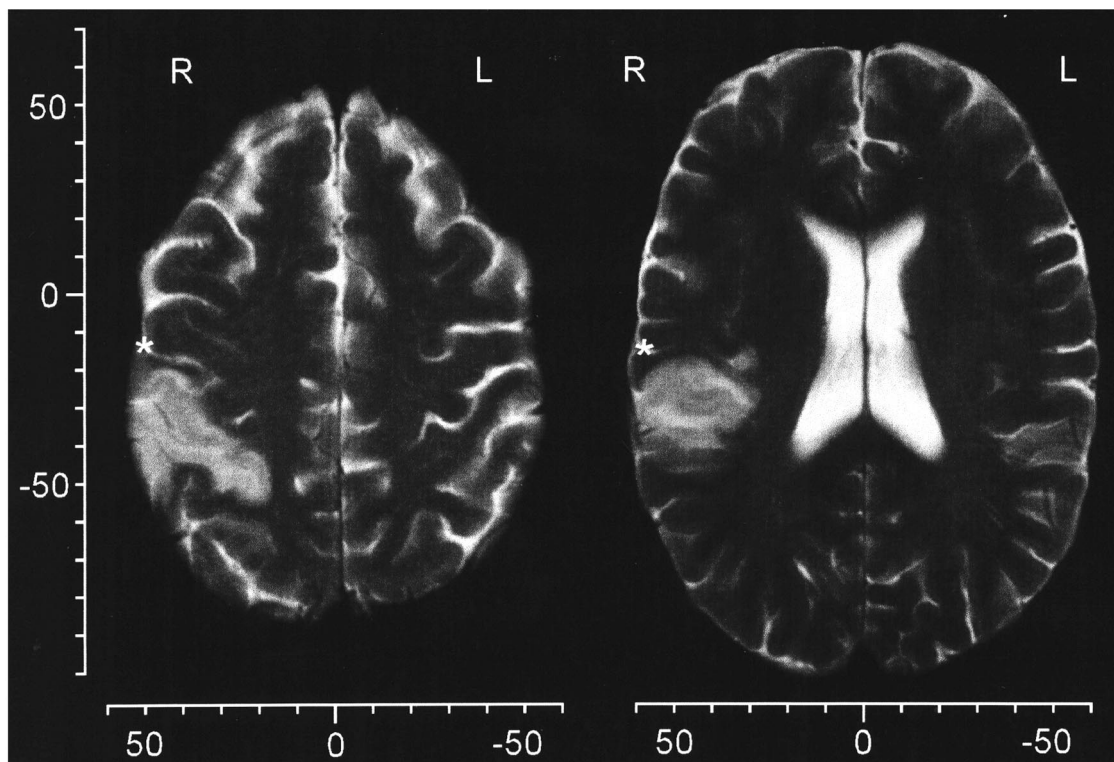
Transaxial MRI-slices at 42 mm (left) and 18 mm (right) parallel above the anterior commissure-posterior commissure-line. Scales give coordinates in mm according to the Talairach frame of reference (Talairach and Tournoux, 1988). Markers (*) indicate the central sulcus.
